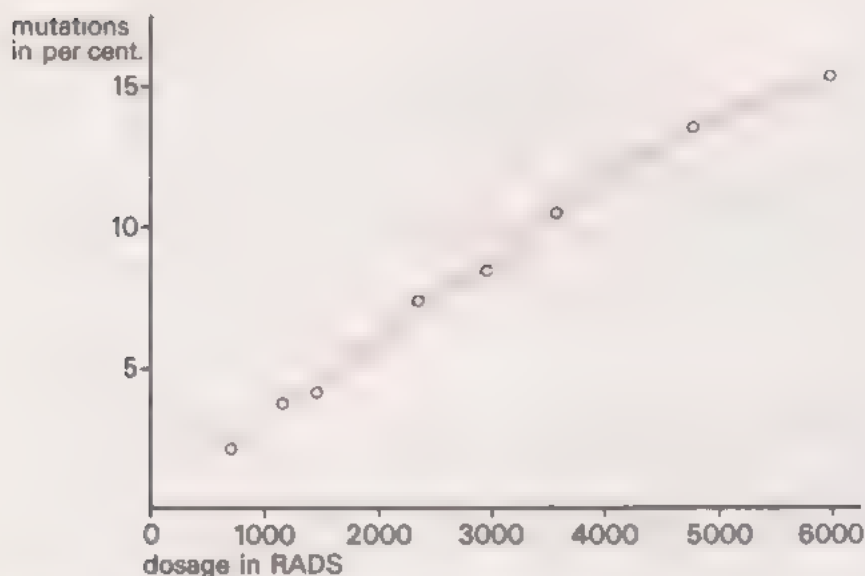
The effect of X-rays on the mutation rate of *Drosophila*.
